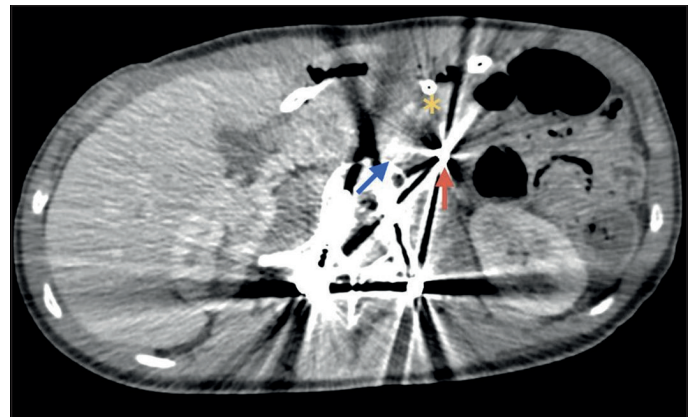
b. CT post placement of clips in D3. Axial view Asterix: SMA, Red arrow: endoscopic clip Blue Arrow: aorta.
